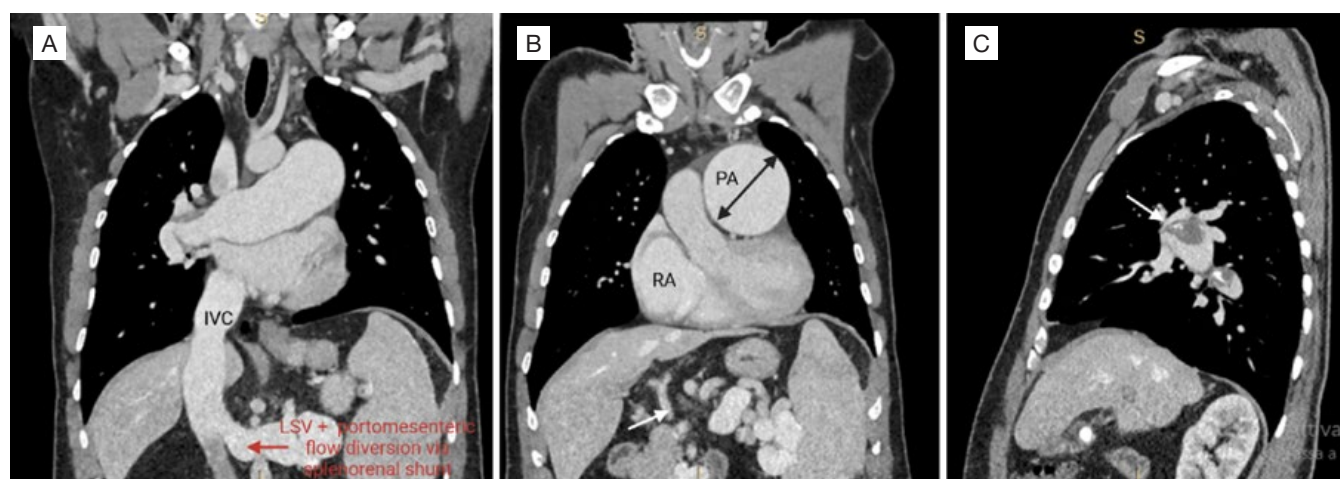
Contrast-enhanced CT images of the thorax and abdomen.
